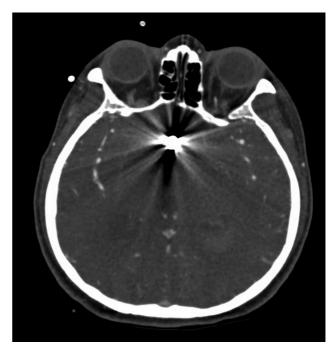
CTA image artifact from aneurysm coil. Example of coil artifact on CTA, from a patient following anterior communicating artery aneurysm coiling. In this case, image artifact impaired ability to assess for focal vasospasm. CTA, computed tomography angiography.
